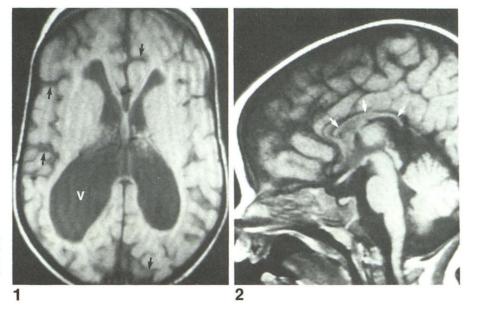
Case 4: 4-month-old girl. Sagittal MR image (600/20) shows that corpus callosum (*arrows*) is abnormally thin throughout its length. Classic findings of partial or complete corpus callosum agenesis are not present.
